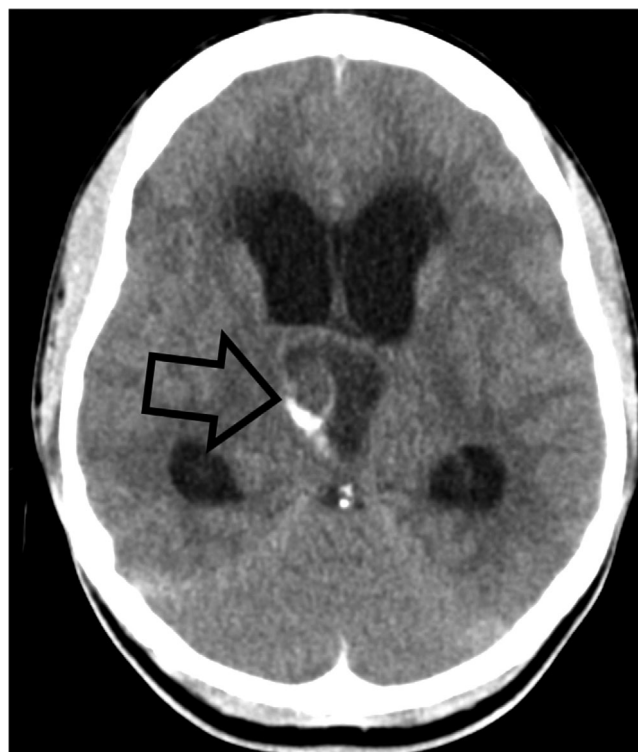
Axial computed tomography (CT) of brain depicts 2.5 cm right intraventricular third ventricle mass (arrow) with mixed density consistent with ependymoma versus dermoid tumor occluding the cerebral aqueduct resulting in third and lateral ventricle hydrocephalus
